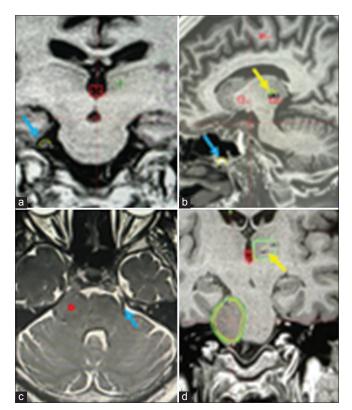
GKR treatment planning images. a) Coronal slide of T1-weighted MRI shows the prescription dose area of the right trigeminal nerve (63 Gy) (blue arrow) and the planning axis of the left thalamus (green cross) located lateral and superior to the posterior inter-commissural line (PC) (red box). b) Sagittal slide of the T1-weighted MRI shows the sphenopalatine ganglion prescription dose area (45 Gy) (blue arrow) and the thalamus prescription dose area (70 Gy) (yellow arrow). The anterior (red box - AC) and posterior (red box - PC) limits of the inter-commissural line can also be observed. c) Axial slide of heavily T2-weighted MRI shows a tumor in the right cerebellopontine angle (red asterisk) deforming the right trigeminal nerve, which is not observed, unlike the left trigeminal nerve (blue arrow). d) Coronal slide of T1weighted MRI of the same patient in image c, shows the tumor of the right cerebellopontine angle (red asterisk), with the prescription dose of 12 Gy (yellow circle) and the safety dose of 10 Gy (green circle). The prescription dose of the thalamus (70 Gy) is shown in the yellow circle indicated by the yellow arrow and the green circle around it corresponds to the safety dose (10 Gy).
